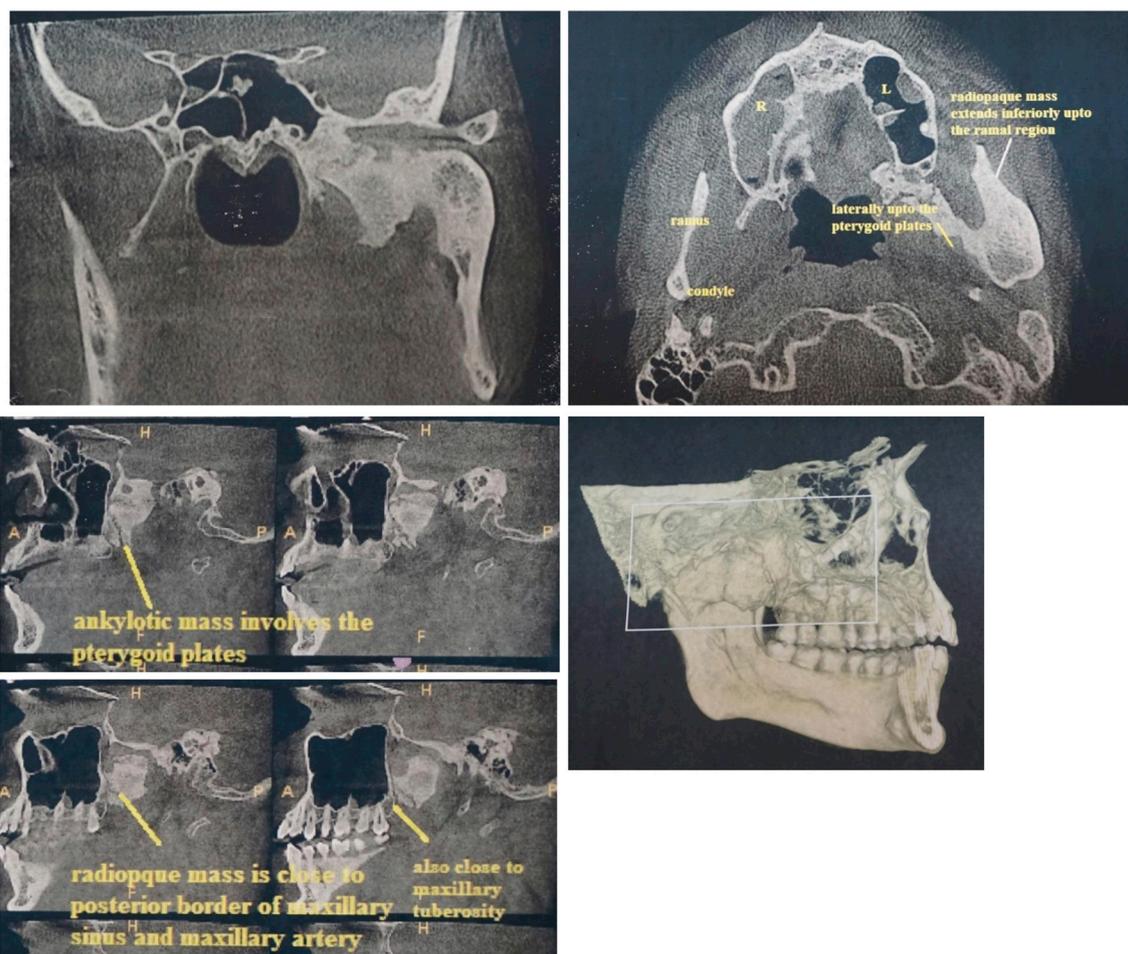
Depicts the preoperative non-contrast CT images in coronal (a), axial (b), sagittal (c & d), and 3D sagittal cut sections (e).
